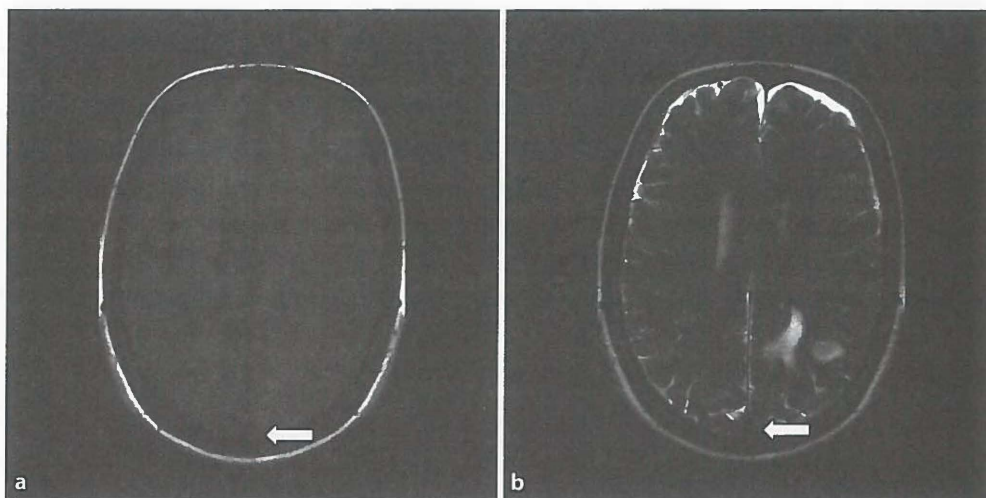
Acute thrombus (arrow) in sagittal superior sinus appears isointense on T1-weighted image (a) and hypointense on T2-weighted image (b)
